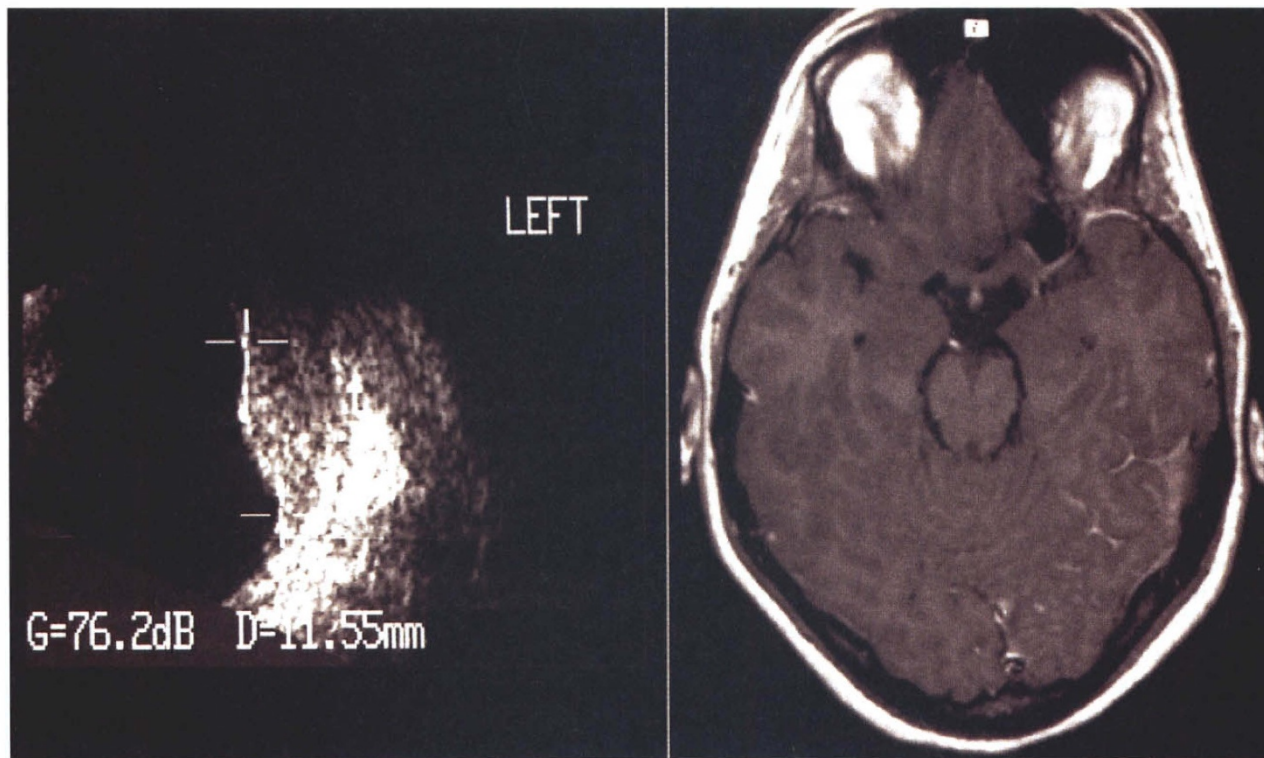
Left: B-scan ultrasound showing the circumscribed lesion with regular internal structure; there is no choroidal excavation. Right: Post-gadolinium axial MRI scan showing enhancement of the parietal and occipital leptomeningeal regions.
